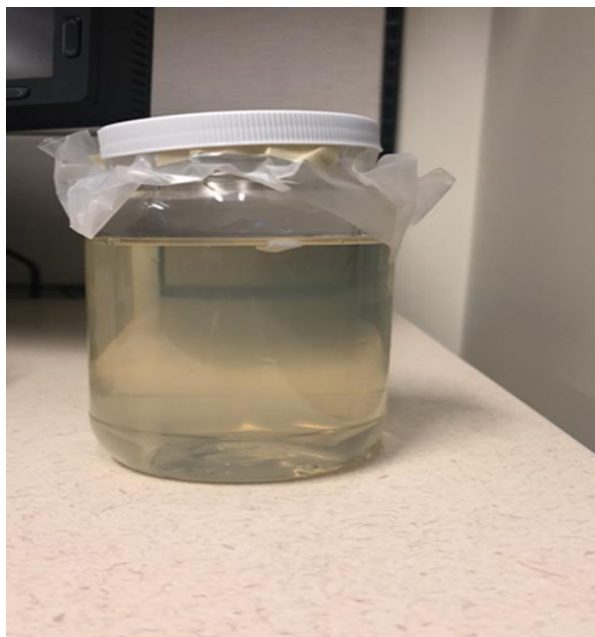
The completed NIPAM gel for CBCT-D
